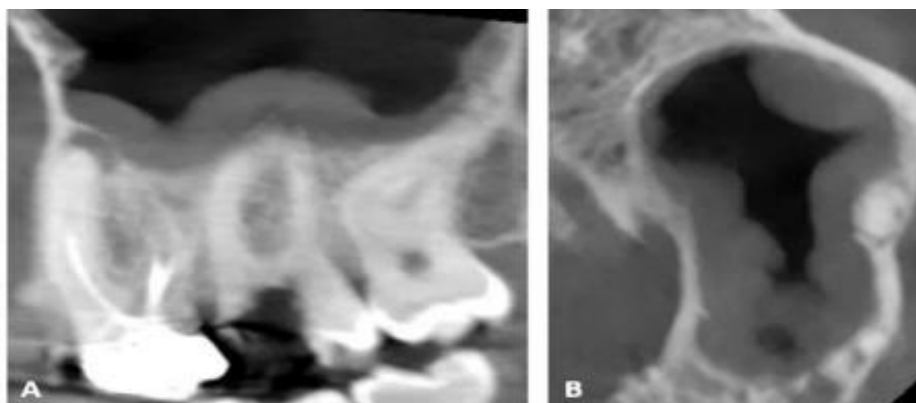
Radiographic evaluation of chronic odontogenic maxillary sinusitis associated with a grossly decayed left maxillary second molar. A - Coronal CBCT view shows extensive mucosal thickening and partial opacification of the left maxillary sinus, in continuity with the apex of a decayed molar. B - Sagittal CBCT view confirms chronic sinus lining thickening with irregular contours and no fluid level, consistent with long-standing inflammation.
